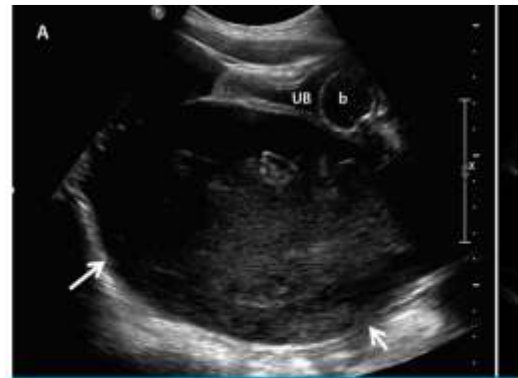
Sagittal pelvic ultrasonography image showing huge cystic lesion (arrows) with internal hyperechoic material compressing collapsed urinary bladder (UB) anteriorly. Balloon (b) of Foley catheter in urinary bladder is also seen
